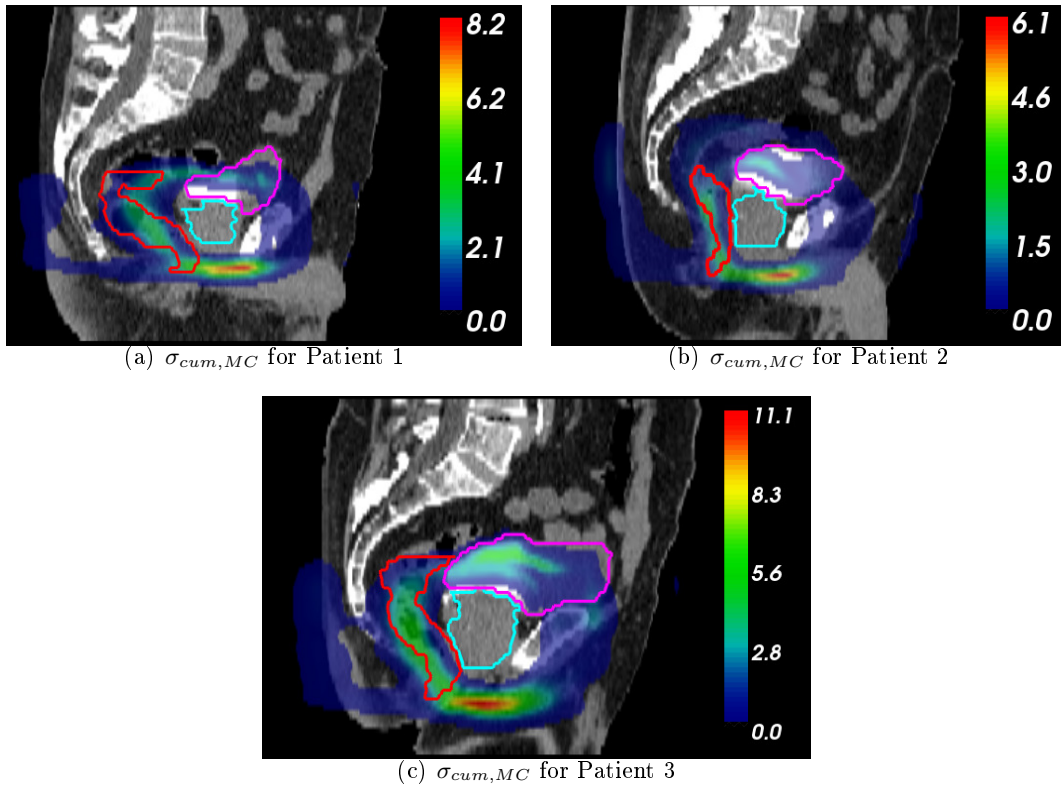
3D sagittal views of $\sigma_{cum,MC}$ for each patient. Segmented prostate (cyan), bladder (purple) and rectum (red) at the planning CT scan are overlaid.
